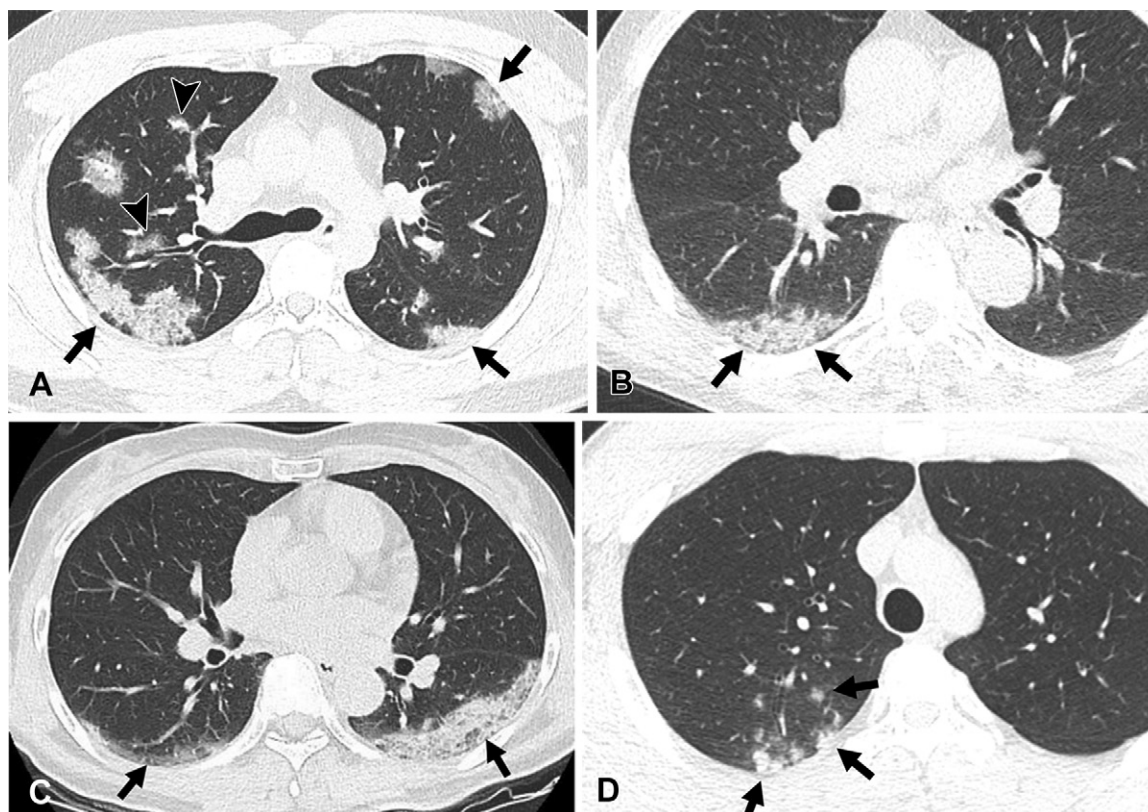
COVID-19 pneumonia during Delta variant– and Omicron variant–dominant periods. (A, B) Images of COVID-19 pneumonia at Delta variant–dominant period. (A) Transverse nonenhanced CT scan (lung window) obtained in a 34-year-old unvaccinated man with no underlying disease shows multifocal areas of mixed ground-glass opacity (GGO) and consolidation with subpleural (arrows) and peribronchial (arrow-heads) distribution. CT findings were classified as “typical” according to the RSNA chest CT classification system. (B) Transverse nonenhanced CT scan (lung window) obtained in a 58-year-old fully vaccinated man with no underlying disease seen at Delta variant–dominant period shows a focal subpleural area of consolidation (arrows) in superior segment of right lower lobe. This case was classified as “indeterminate” according to the RSNA chest CT classification system. (C, D) COVID-19 pneumonia at Omicron variant–dominant period. (C) Transverse nonenhanced CT scan (lung window) obtained in 56-year-old unvaccinated woman with no underlying disease shows subpleural areas of mixed GGO and consolidation (arrows) in both lower lobes. CT findings were classified as “typical” according to the RSNA chest CT classification system. (D) Transverse nonenhanced CT scan (lung window) obtained in a 20-year-old man with no underlying disease who received a booster dose shows poorly defined centrilobular nodules in the right upper lobe (arrows). This case was considered “atypical” according to the RSNA chest CT classification system.
